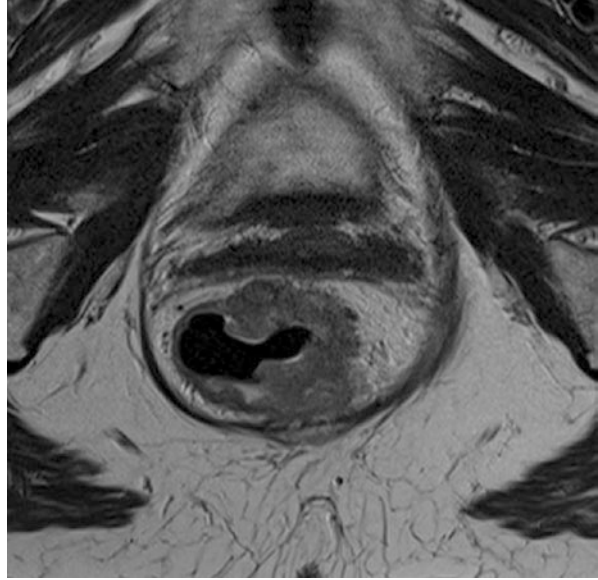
Sagittal MR imaging non-mucinous and mucinous (high T2 signal) rectal cancers
